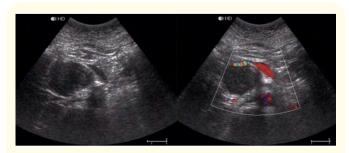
US-imaging of pancreatic head lesion: right - B-mode; left - Color Doppler Imaging.
